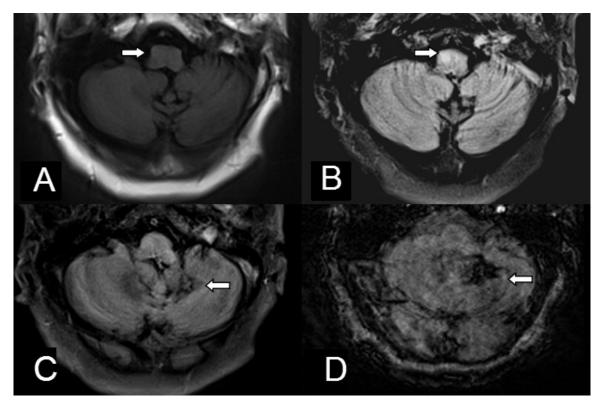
MRI revealed the typical signs of HOD. Isointensity in the enlarged right olivary nucleus is shown on the axial T1-weighted image (A), and hyperintensity is shown on the corresponding T2-weighted fluid-attenuated inversion recovery (FLAIR) image (B) (white arrow). The remote hemorrhage of the left dentate nucleus was better visible on susceptibility-weighted images (SWI) (D) than on the T2-weighted FLAIR image (C) (white arrow).
